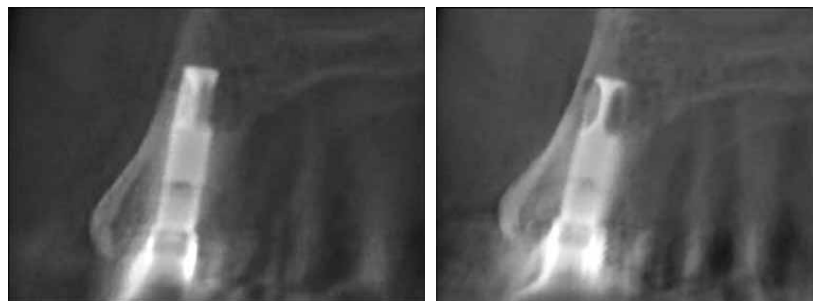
Dental computed tomography (dental scan) of the right sided exostosis of Case 1 depicting progressive expansion of the cortical plate and increased bone density (A, 2 years after implant placement; B, 3 years after implant placement).
